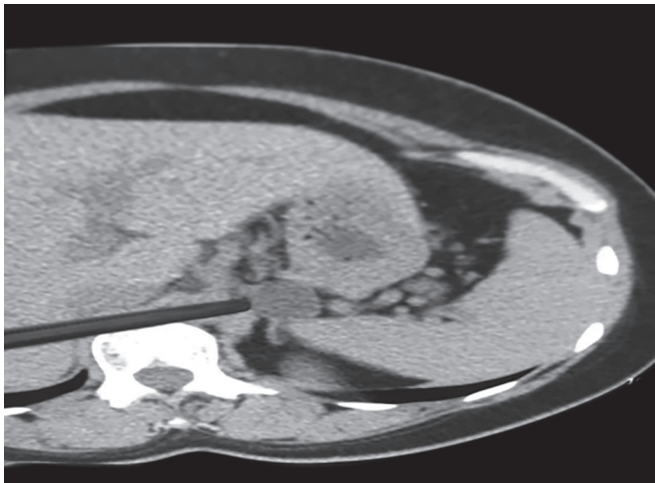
Computed tomography scan showing left adrenal mass and normal right adrenal gland
